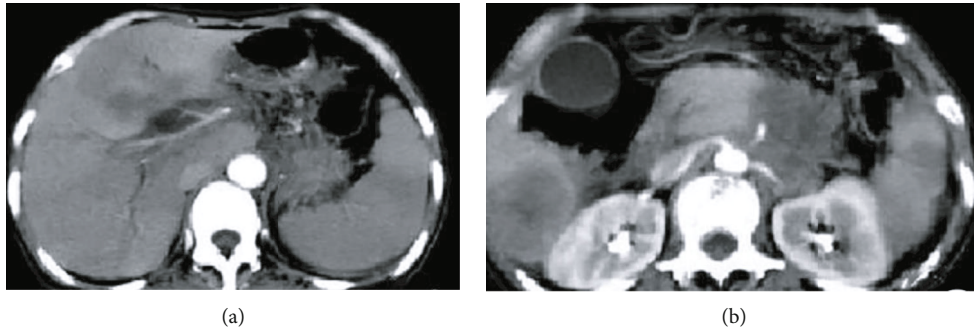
Conventional MRI image. Note: (a, b) conventional MRI images, showing poorly defined boundaries of the pancreas.
